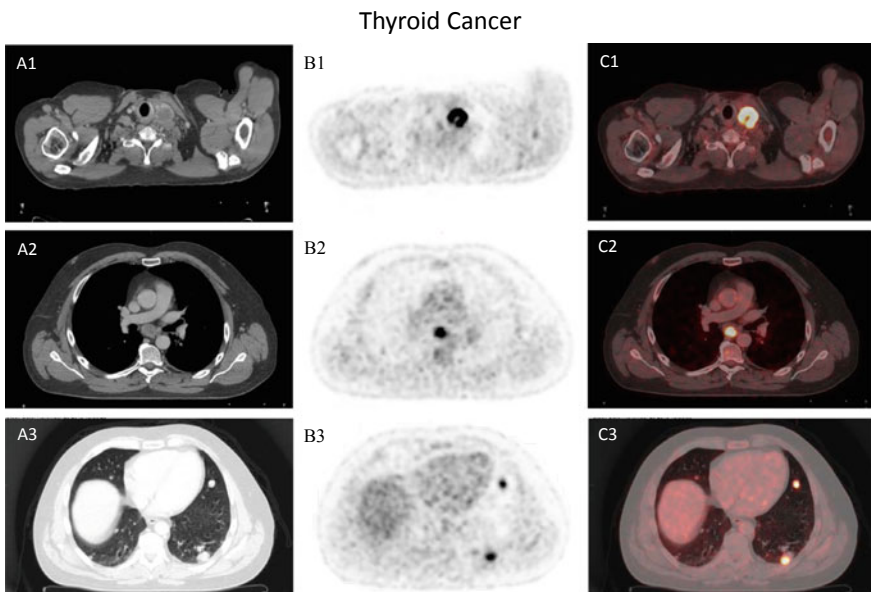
53-year old male patient with minimally invasive follicular thyroid cancer, referred to FDG PET/CT for re-staging with known Iodine-131 positive local recurrence and a thyroglobulin level of 319 $\mu\text{g/l}$ under TSH suppression. Besides the local recurrence FDG PET/CT showed an infracarineral FDG-positive lymph node metastasis and multiple FDG-positive pulmonary metastases; (A1-3) CT-Scan, (B1-3) PET scan, (C1-3) PET/CT fused images
